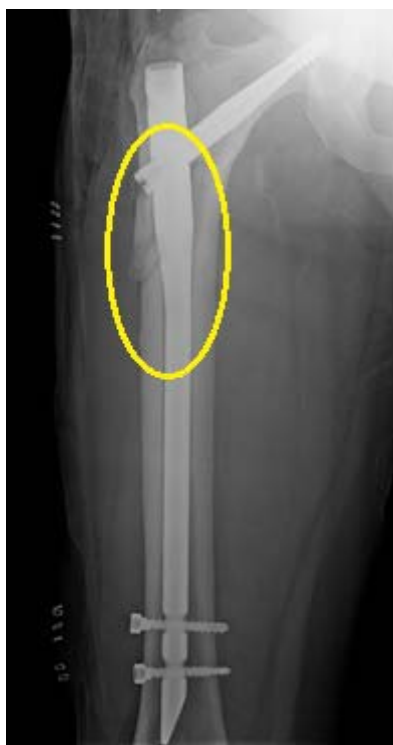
X-ray of the right femur on day 0 post-op showing an iatrogenic fracture of the proximal third of the femoral shaft
